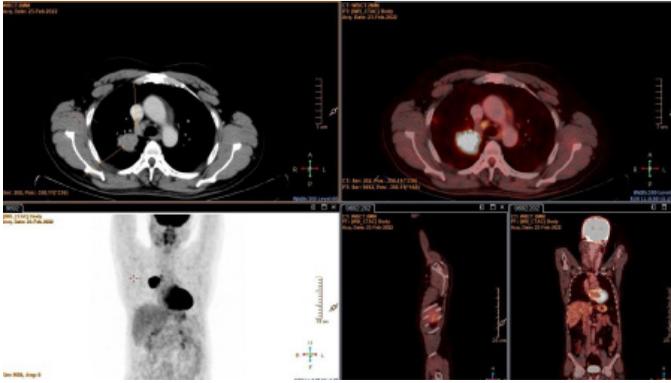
Ca Lung (Rt) (CT scan; Lung mass seen, suspicious for primary lung malignancy with the paratracheal lymph node considered normal by CT size criteria. PET-CT scan; Hypermetabolic lung mass with paratracheal nodal metastasis)
